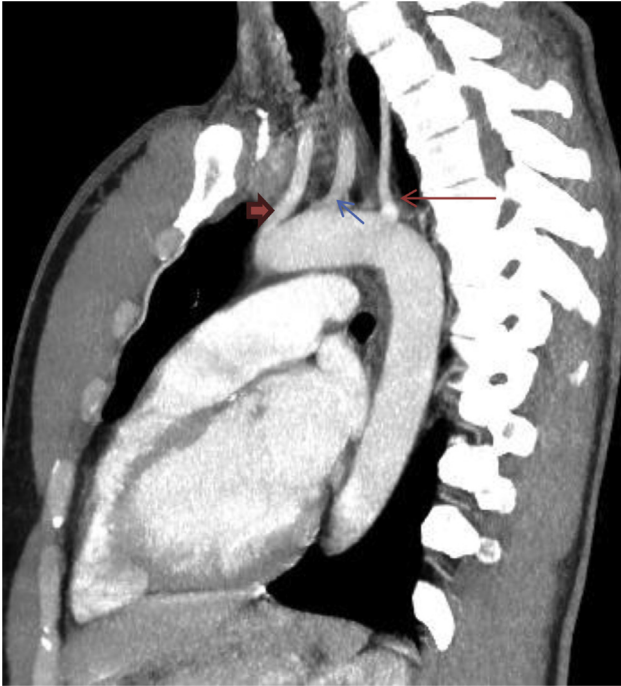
Case 1: Sagittal oblique maximum intensity projection (MIP) image of the computed tomography (CT) scan of the chest showing aberrant right vertebral artery arising as the last vessel of the arch (thin red arrow), distal to left subclavian artery (blue arrow). Also, note left common carotid artery (thick red arrow).
